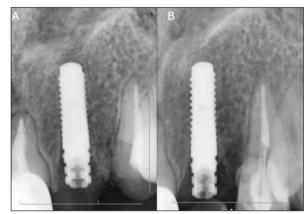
A) Postoperative periapical evaluation of the implant. B) Immediately implanted implant after 3 months and control periapical radiograph of tooth number 23 with fiber post.
